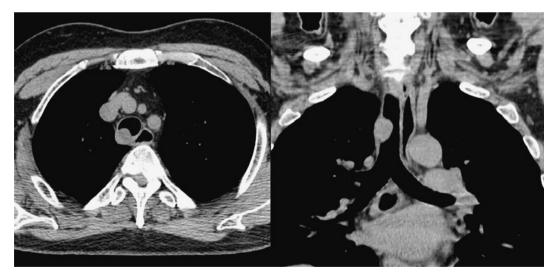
A computed tomography (CT) scan showing a 1.8 cm polypoid lesion arising from the posterior wall of the lower trachea.
